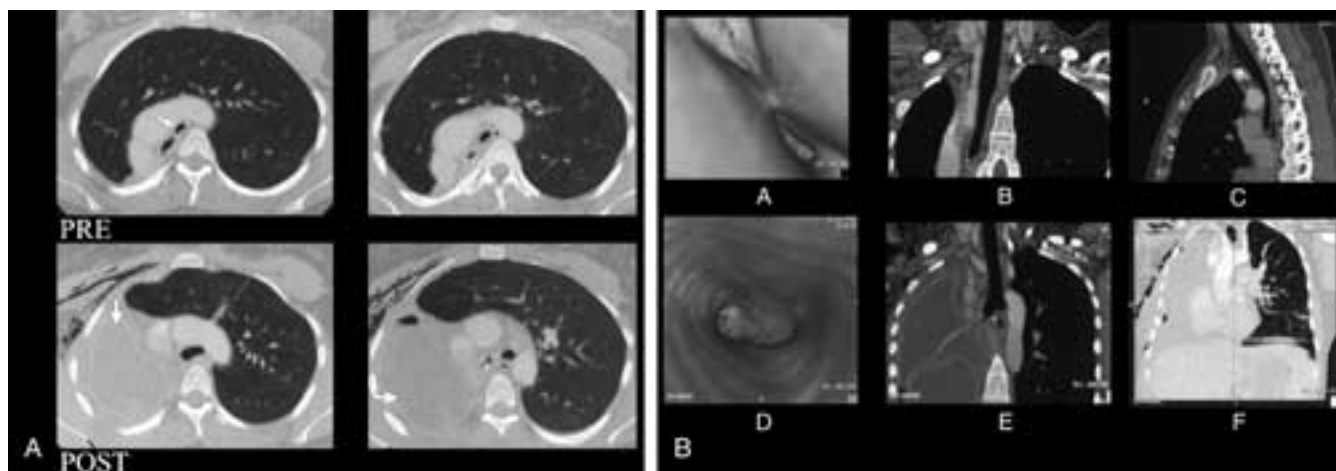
Postpneumonectomy syndrome. A 28-year-old female with congenital hypoplasia of the right lung who underwent right pneumonectomy following recurrent pulmonary infections. Several months after surgery, the patient developed severe shortness of breath. A, Contrast-enhanced axial CT scan of the chest shows right mediastinal shift, with herniation of the left lung into the right hemithorax (*upper row*). Note the compression of the proximal left mainstem bronchus between the transverse aorta and the vertebral body (*arrow, left upper row*). The mediastinal shift was corrected by insertion of saline breast implants (*short arrows, lower rows*) into the right pneumonectomy space. Following this, the trachea was midline and the compression of the left mainstem bronchus was resolved. B, Three-dimensional reconstructions from the dataset in A before and after placement of saline implants.
